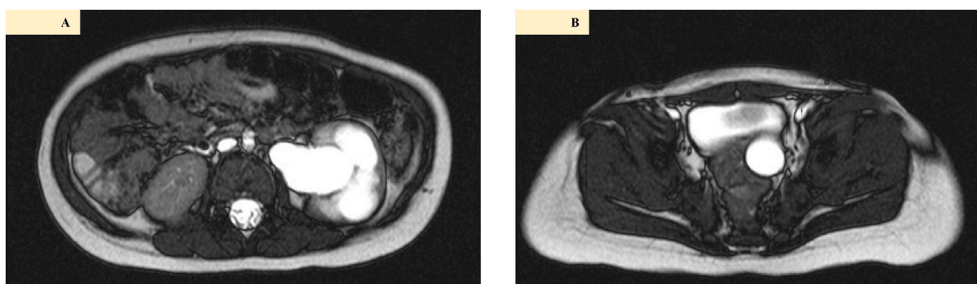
Magnetic resonance imaging reveals a left hydronephrosis and hydroureter (A), the left ureter was dilated up to the ureterovesical junction (B).
